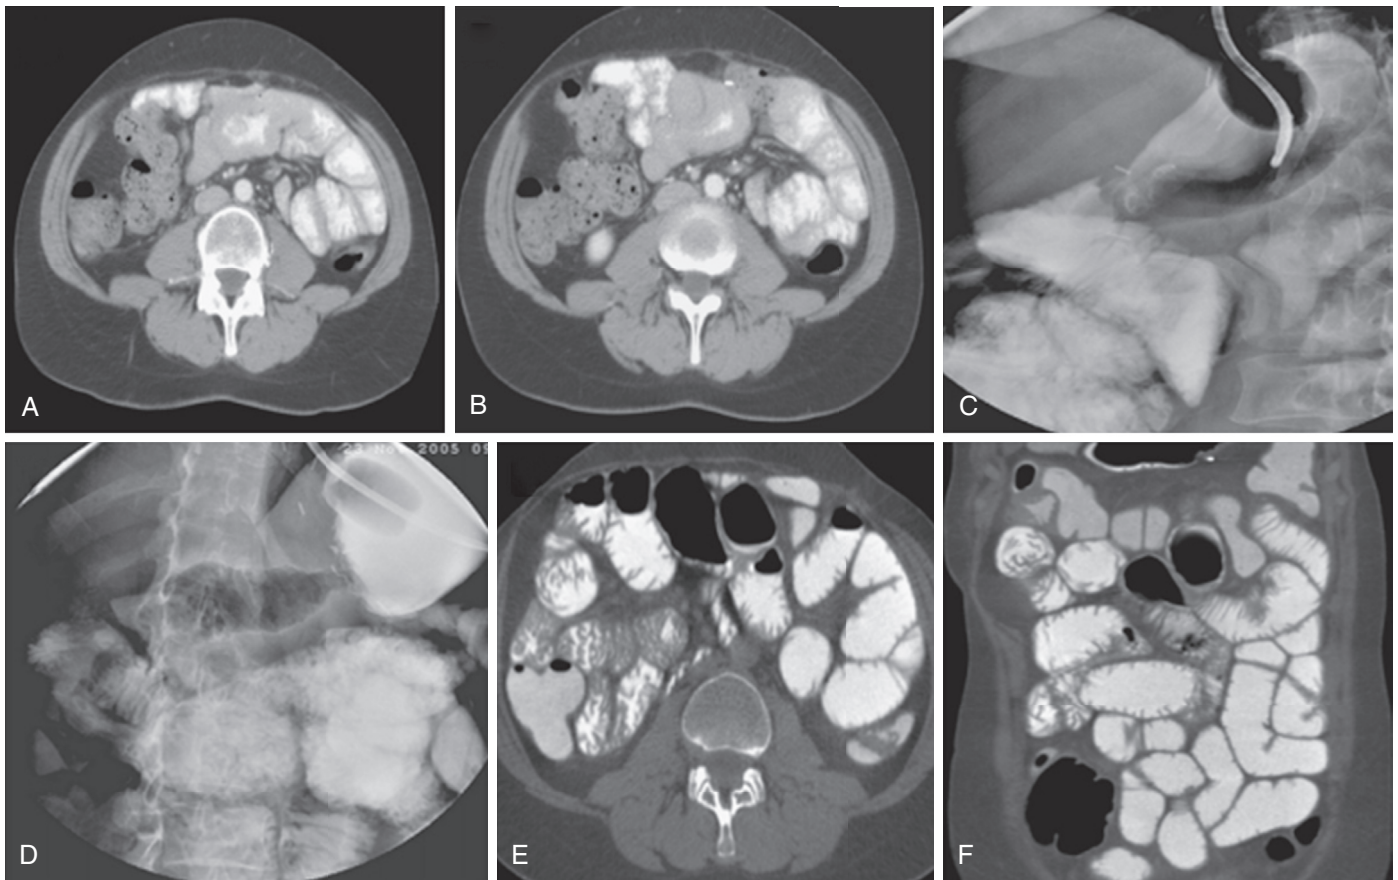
CTE in the evaluation of late postsurgical complications. A, B. Axial CT images with oral and IV contrast in a patient with abdominal distention, nausea, and vomiting and a history of prior ulcer surgery. An apparent abnormality is seen in the proximal SB. The possibility of intussusception and a mass were reported. C. Image during fluoroscopic phase of positive enteral CTE shows the balloon distal to the gastroesophageal junction. D. Frontal radiograph shows dilated gas and fluid-filled proximal SB, without evidence of a mass or intussusception. Stasis was seen at fluoroscopy at this level, suggesting postsurgical dysmotility. E, F. Axial and coronal images of CTE show dilated proximal SB loop compatible with dysmotility noted on real-time (fluoroscopic) evaluation, without evidence of a mass or intussusception. An abnormality noted is secondary to admixture defects secondary to stasis related to dysmotility from a prior Billroth 1 procedure done with vagotomy. (Data from Gollub MJ, Maglinte DD: CT enterography and CT enteroclysis. In Shirkhoda A [ed]: *Variants and Pitfalls in Body Imaging*, 2nd ed. Philadelphia, Lippincott Williams & Wilkins, 2011, pp 328–362).
